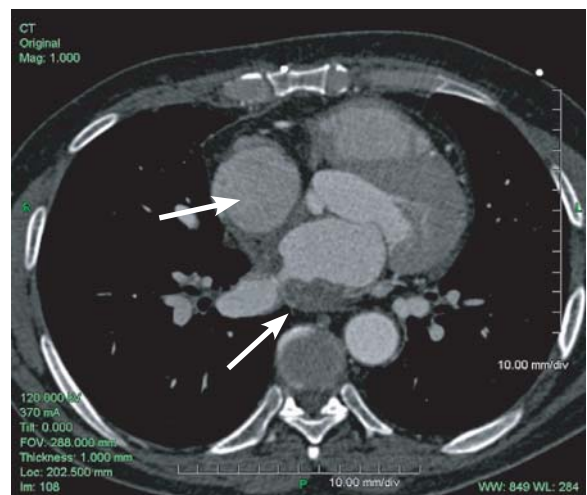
Left atrial osteosarcoma (white arrows) invading the right inferior pulmonary vein. Data were obtained using 16-slice CT with 16×0.75 -mm collimation and 0.42-s rotation time
